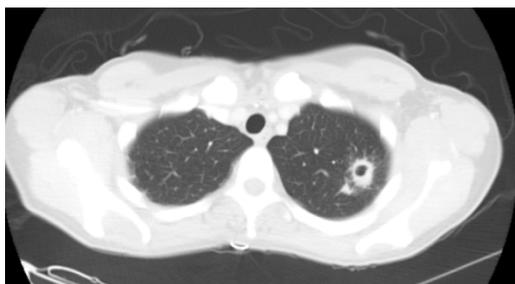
Chest CT scan without contrast showing left upper lobe cavitory lesion
